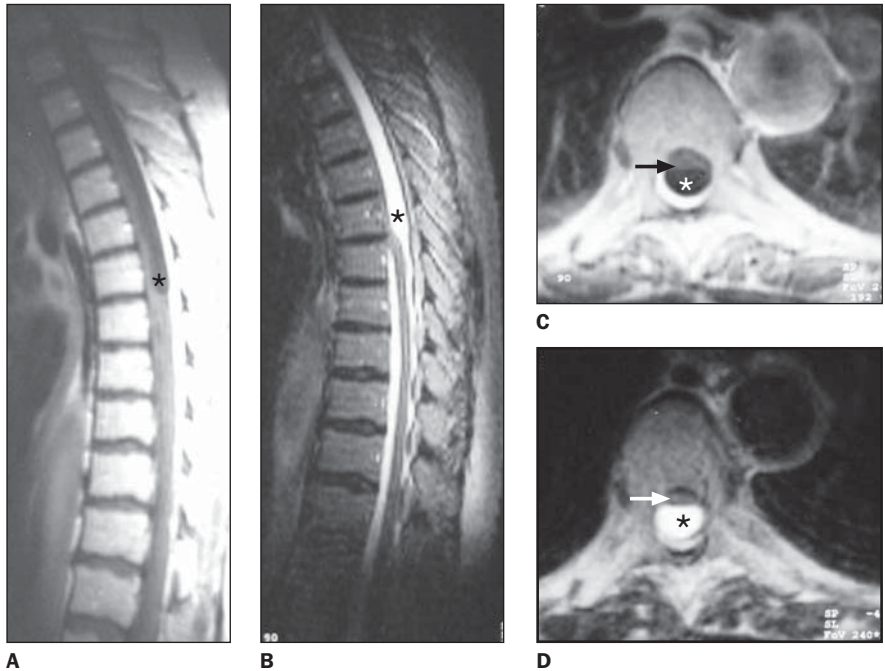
Dorsal column MRI. A: Sagittal plane, T1-weighted sequence showing clustered cysts (asterisk) corresponding to an area with hypointensity. B: Sagittal plane, T2-weighted sequence showing hyperintense clustered cysts (asterisk) compressing the dorsal spinal medulla. C: Axial plane, T1-weighted sequence showing hypointense clustered cysts (asterisk). D: Axial plane, T2-weighted sequence showing hyperintense clustered cysts (asterisk) compressing the dorsal spinal medulla (arrows).
